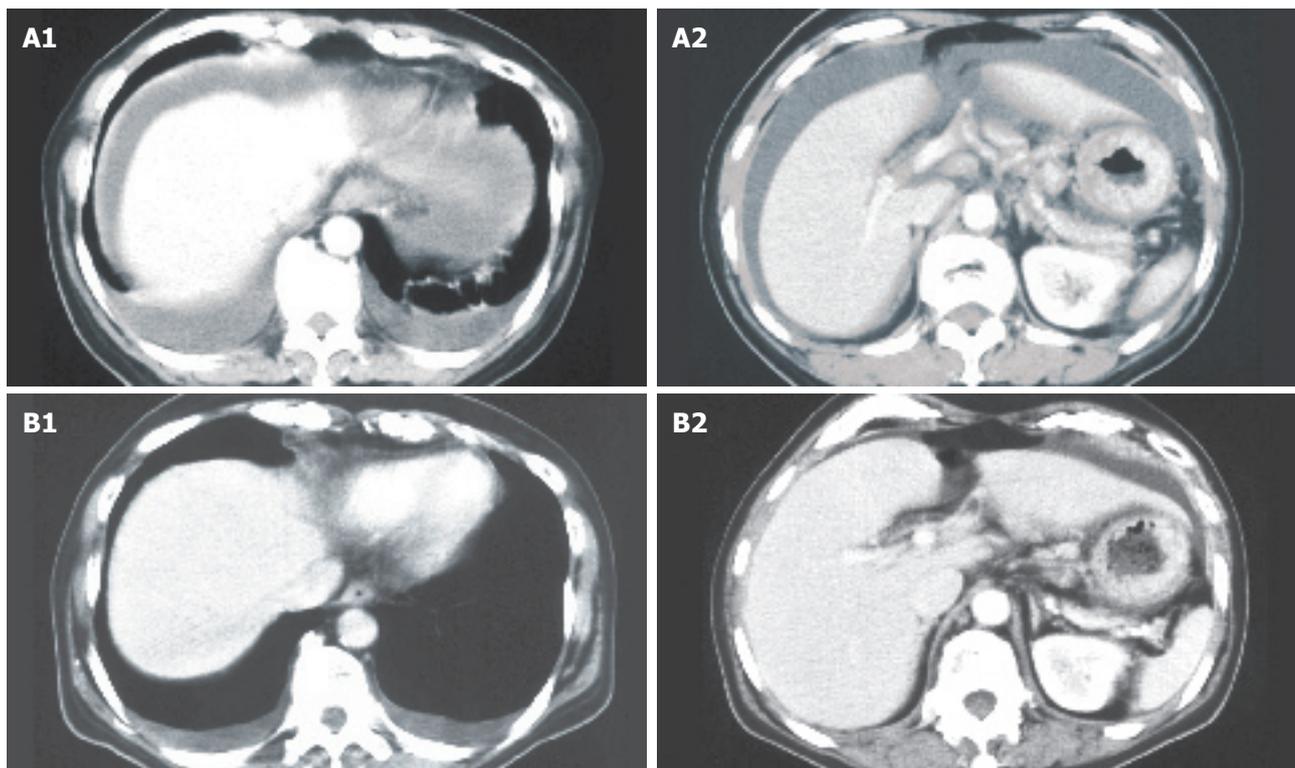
CT scanning of case 1 showing markedly decreased amount of ascites after 2 courses of the combined chemotherapy of 5-fluorouracil and PTX. A1, A2: before chemotherapy; B1, B2: after chemotherapy.
